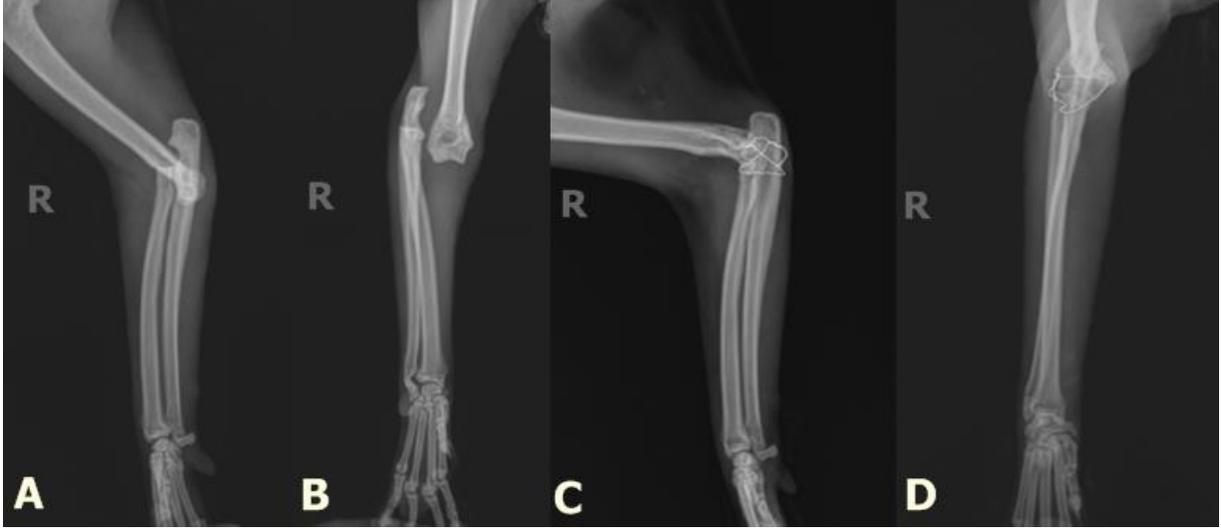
Preoperative (A,B) and postoperative radiographs of the case 3 (C,D).
